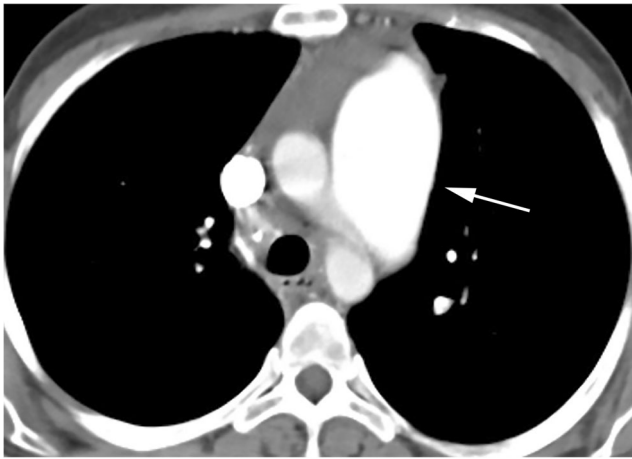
Contrast-enhanced CT of a scleroderma patient with pulmonary hypertension demonstrates enlarged main pulmonary artery (*arrow*). CT computed tomography
